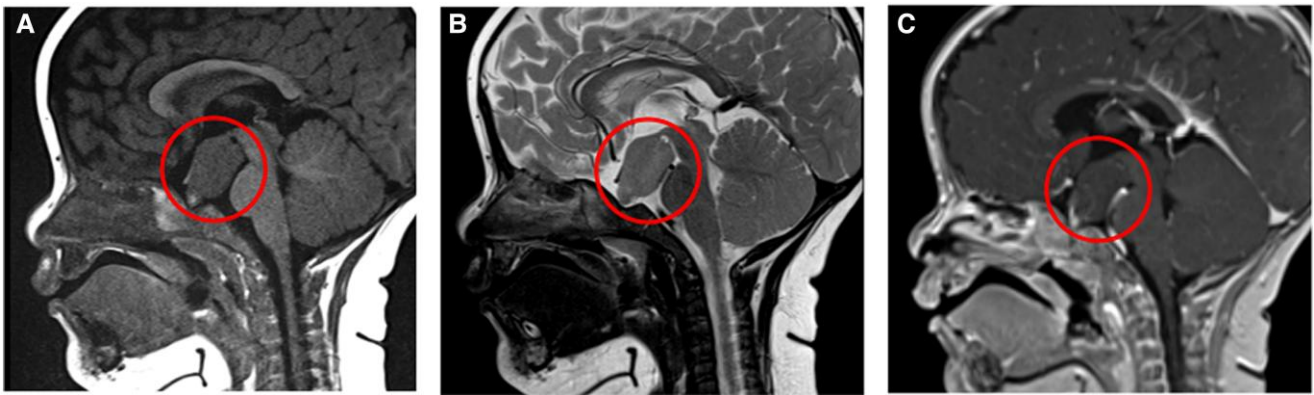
Magnetic resonance imaging of hypothalamic hamartoma (HH) of the patient (A, T1-weighted sagittal image; B, T2-weighted sagittal image; C, T1-weighted sagittal images with contrast agent). A mass lesion approximately 20 mm in size is shown in the suprasellar area. It was isointense compared to the gray matter on T1-weighted imaging (WI) and of slightly higher intensity than the gray matter on T2-WI. No contrast was used.
